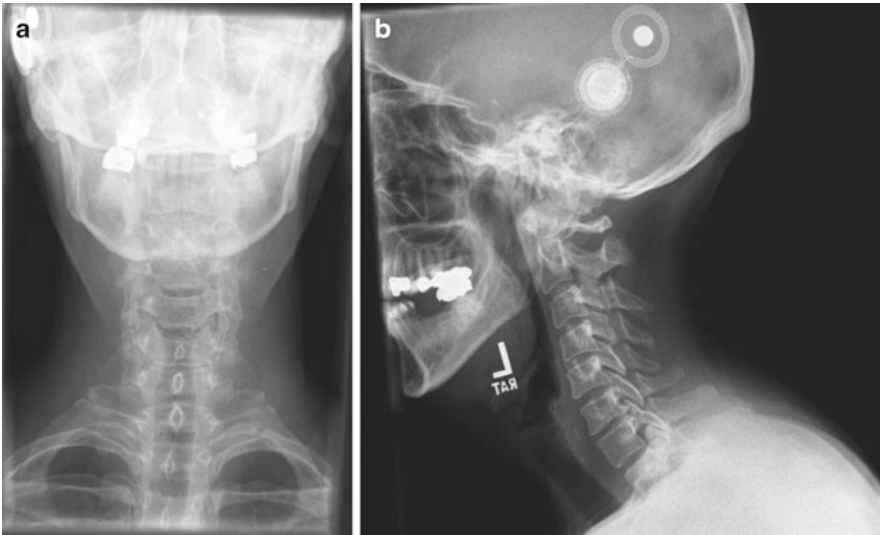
(a) AP radiograph C-spine. (b) Lateral radiograph C-spine
